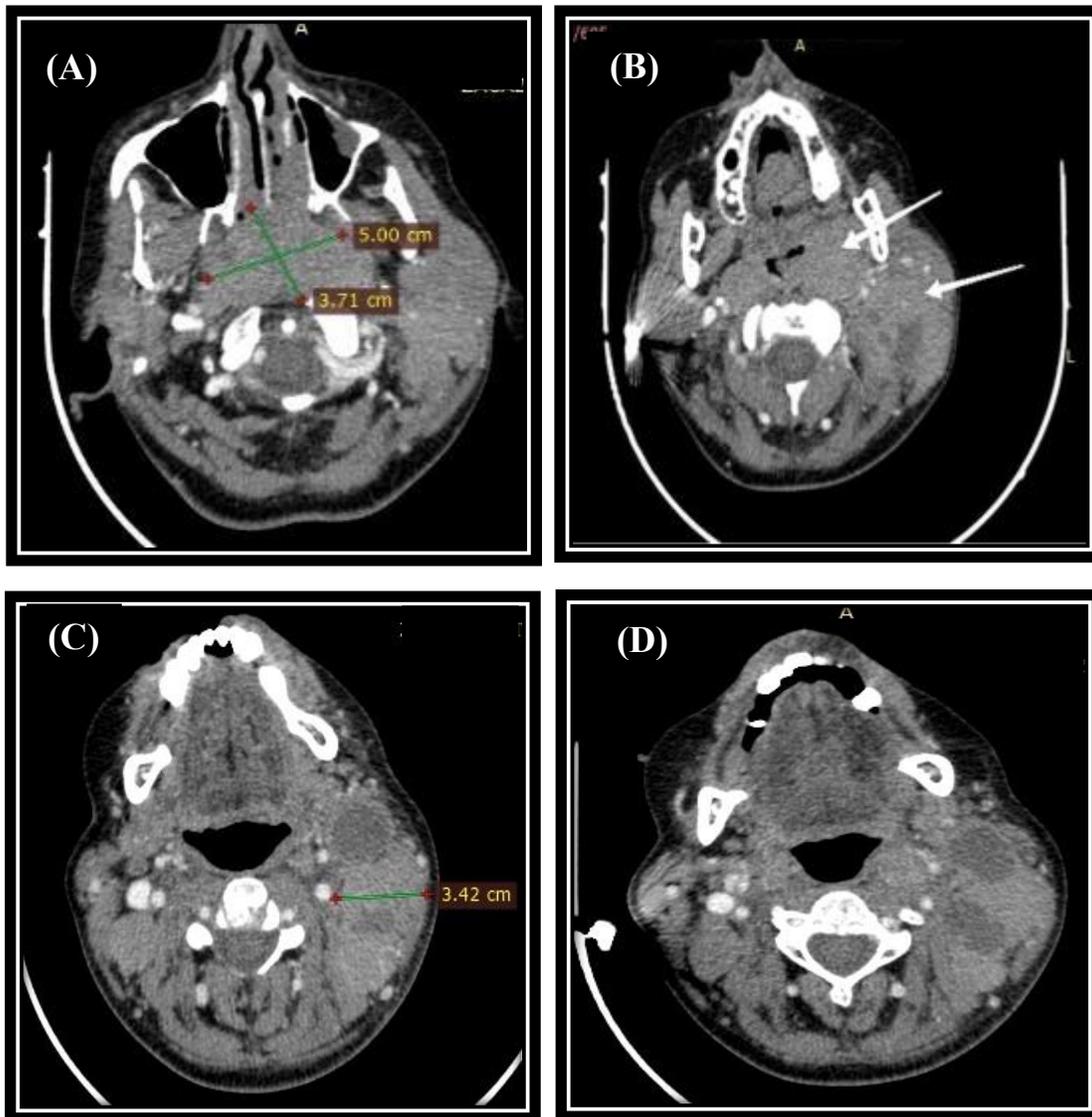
70 yrs old female presented by lump in her neck at LT side, nasal congestion, blood in saliva, partial hearing loss. Multidetector CT axial views with IV contrast (A) MDCT Axial cuts show nasopharyngeal mass measurement (5x3.7cm). (B) it's encroaching upon oropharynx with large amalgamated LNs showing internal cystic degeneration. (C) Multiple amalgamated lymph nodes measures (34mm at short axis). (D) another clear view to internal cystic degenerated LNs.
